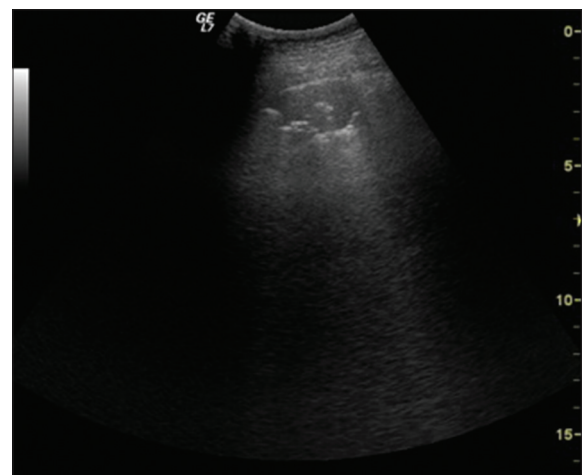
Pleural-based, wedge-shaped, hypoechoic infarct area with central hyperechoic bronchiolar pattern in the sonographic examination of a pulmonary embolism case
